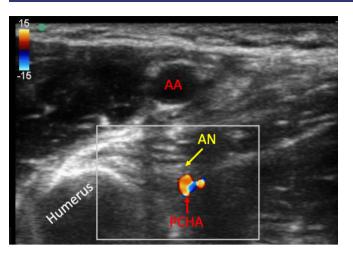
Ultrasound image of the axillary nerve (AN) in close relationship to the posterior circumflex humeral artery (PCHA) in the axillary region. AA, axillary artery; left side, cranial.
